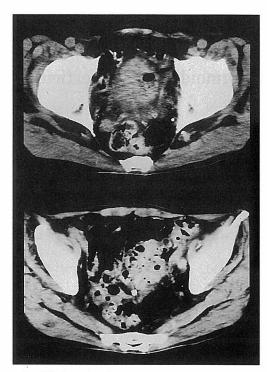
Abdominal computed tomography reveals intravesical air (upper) and multiple air bubbles in the adjacent sigmoid colon (bottom).
